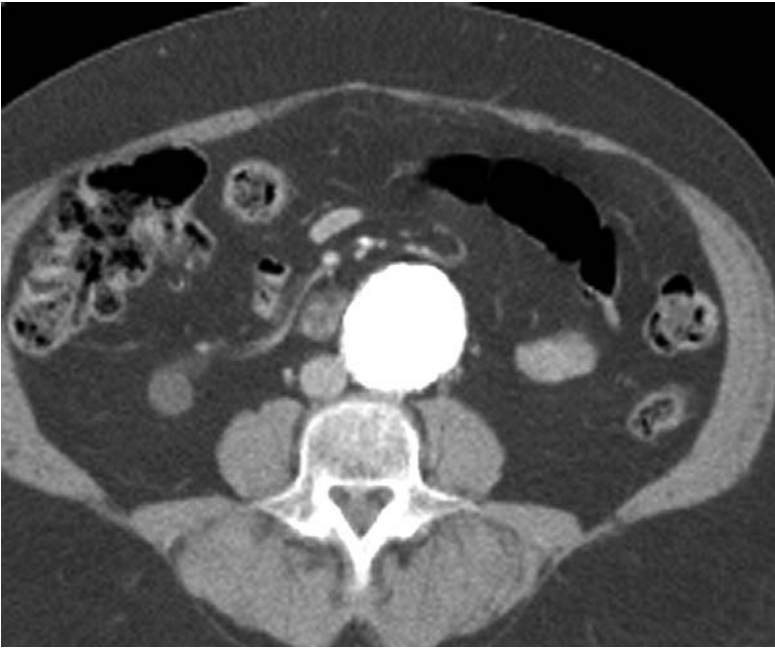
CT demonstrates an abdominal aortic aneurysm (AAA). The aneurysm was noted during workup for back pain, and CT was ordered after the AAA was identified on radiographs. No evidence of rupture is seen
